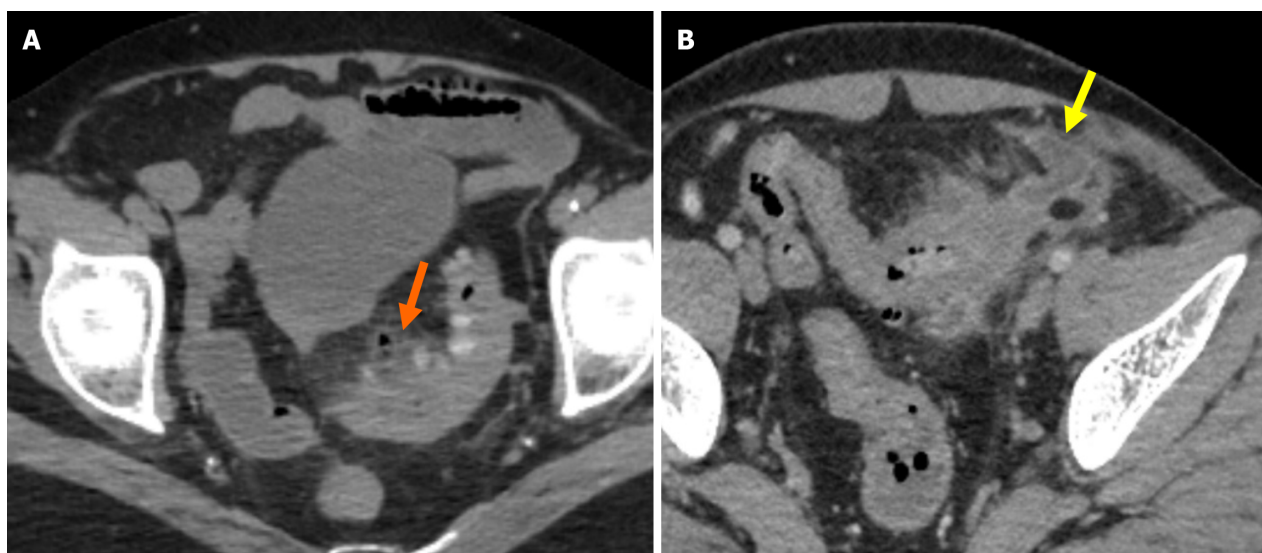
Sartelli stage 1A and stage 1B diverticulitis. A: On contrast-enhanced axial computed tomography (CT) imaging, colonic wall thickening, fat stranding, and pericolic air bubbles were observed in the sigmoid colon, consistent with Sartelli stage 1A diverticulitis (orange arrow); B: Contrast-enhanced axial CT imaging revealed findings consistent with Sartelli stage 1B diverticulitis, including colonic wall thickening, pericolic fat stranding, and a fluid collection measuring approximately 2.5 cm on the anterior aspect of the sigmoid colon, indicative of an abscess (yellow arrow).
